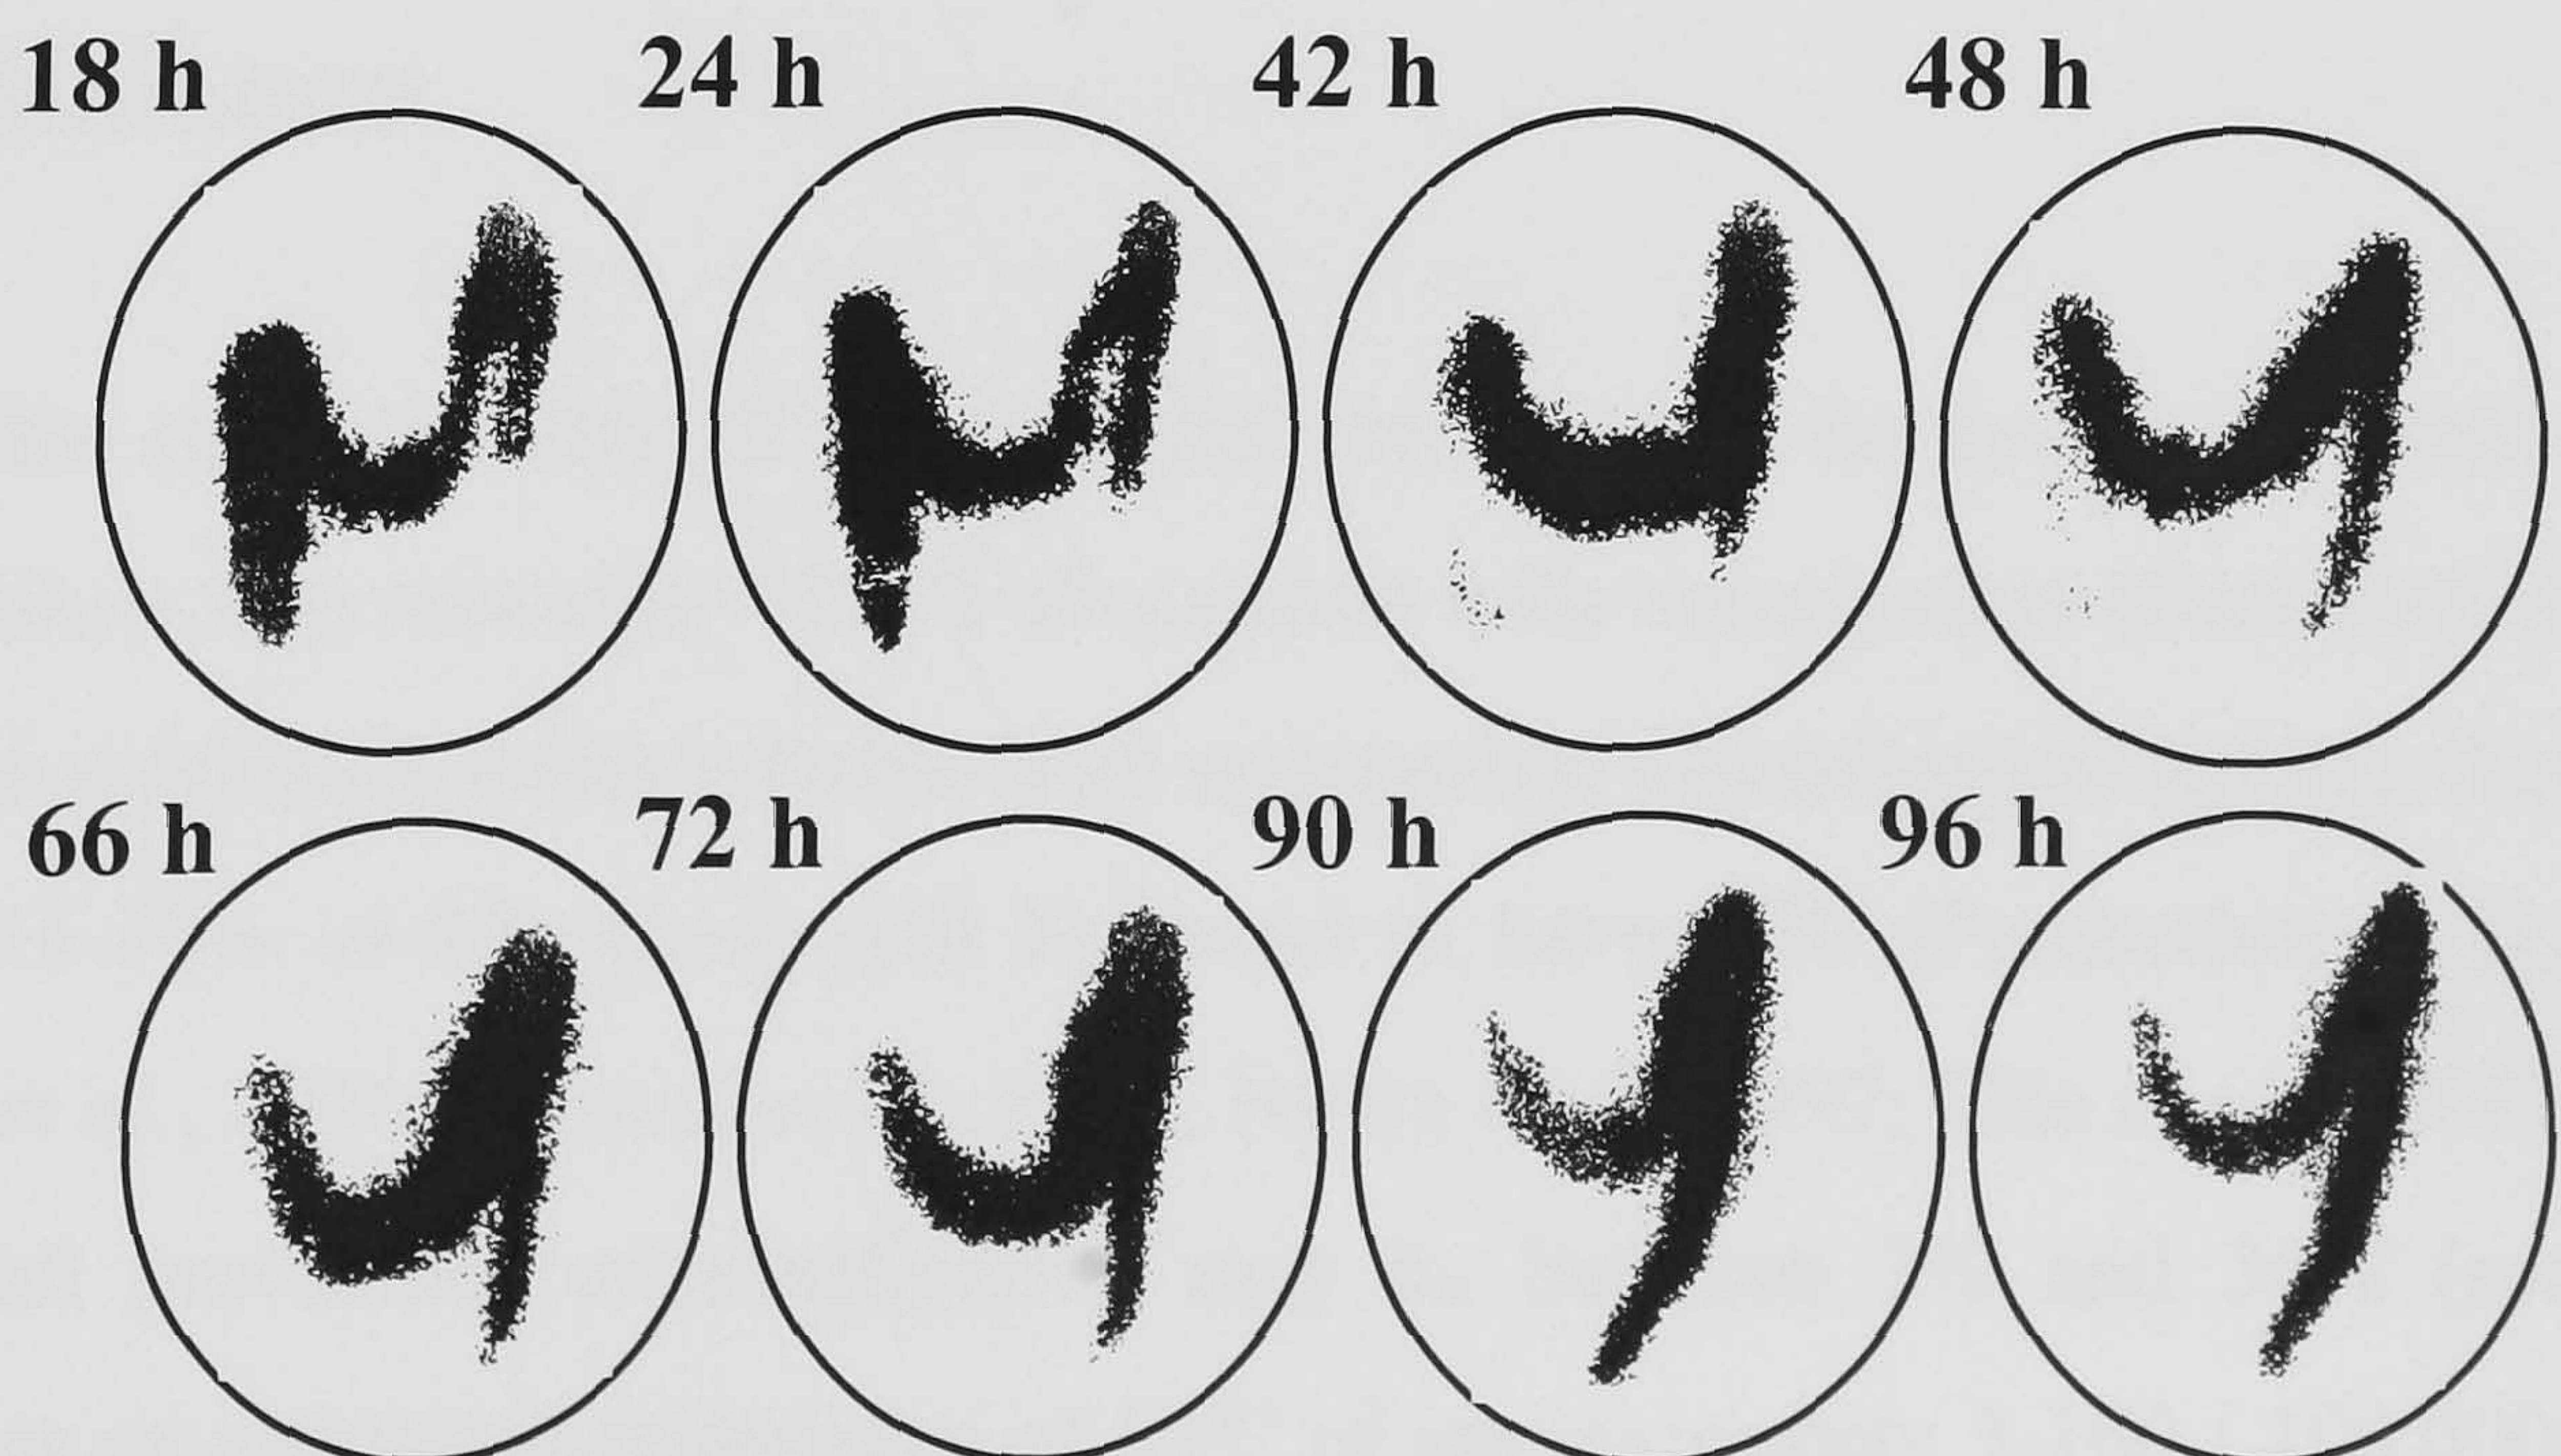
(b) ^{111}In -DTPA radioisotope scintigraphy. Normal healthy control with complete isotope excretion by 48 hours, and a patient with STC, in which isotope progresses slowly around the whole colon with no focal areas of hold-up.
